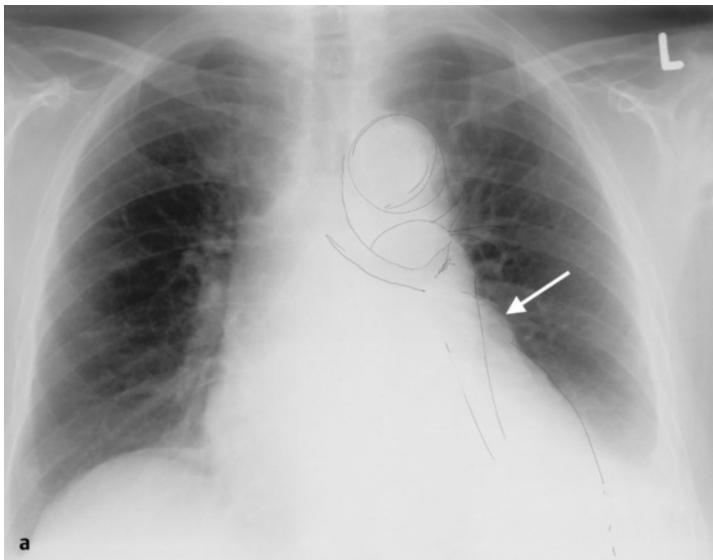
a,b Pronounced left atrial appendage in atrial enlargement. The posteroanterior view (a) shows protrusion of the left pulmonary bay (white arrow) through the enlarged left atrium (atrial appendage). CT (b) shows circumscribed enlargement of the atrial appendage (white arrow).
